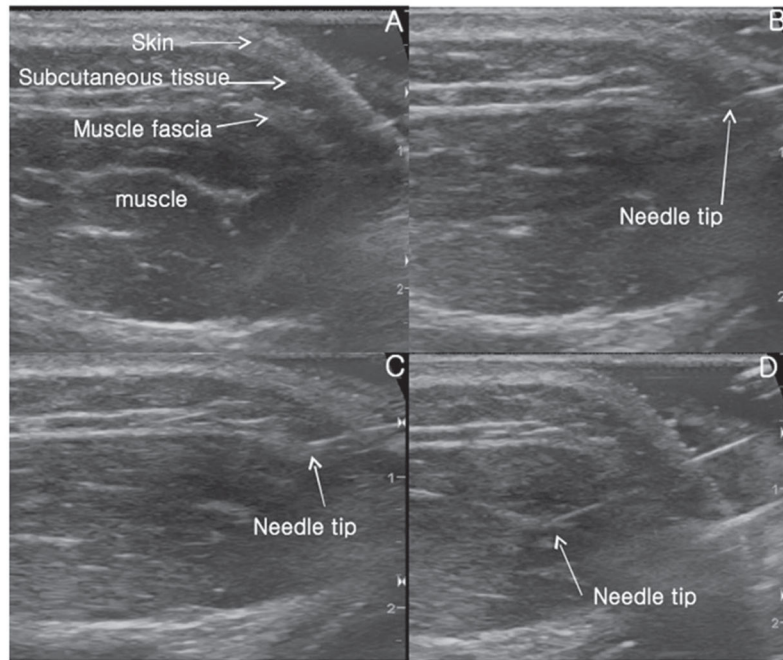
Ultrasound images displaying (A) anatomical tissue layers; (B) needle insertion through subcutaneous tissue; (C) needle insertion to first fascia; (D) needle insertion to intramuscular tissue.
